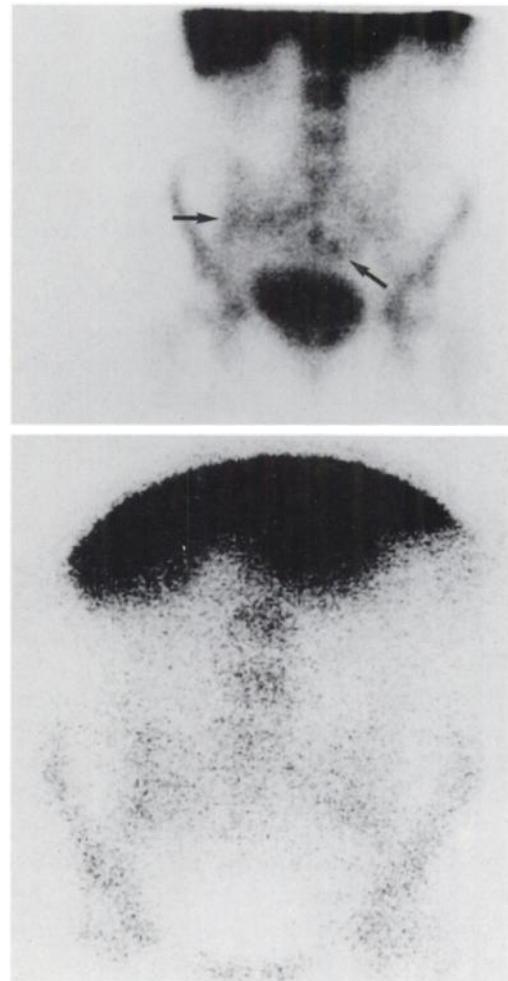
Patient 1. Crohn's disease of the small bowel. Discordant images. Clear pathologic activity in the ileum (between the arrows) on the ^{99m}Tc -WBC image (top). Normal ^{111}In -granulocyte scintigram (bottom).
